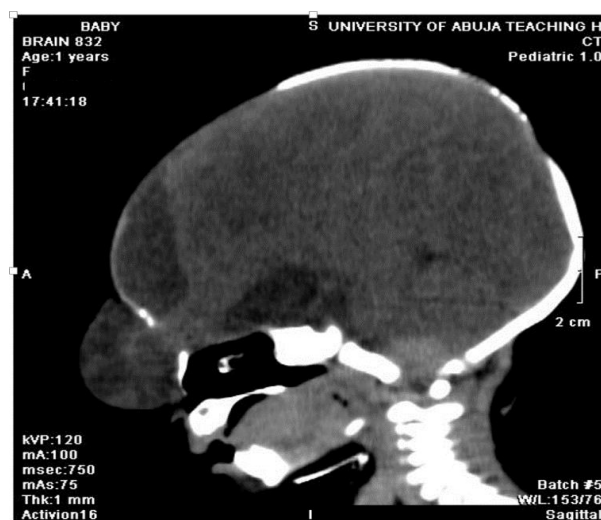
mid-sagittal computed tomography of the brain (soft tissue window) shows protrusion of frontal lobe of the brain through the cranial defect.
